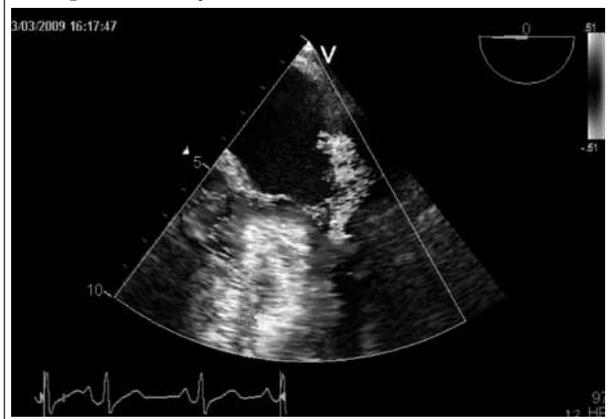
Transoesophageal echocardiography showing mitral valve regurgitation due to perforation of the mitral valve posterior leaflet
